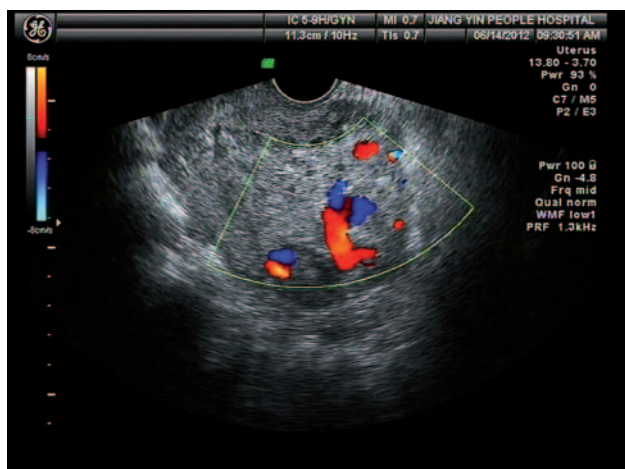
Ultrasound images of a large hematoma, measuring $7.5 \times 6.5 \times 6.1$ cm, in the anterior wall of the middle-lower uterine cavity. Color Doppler flow images (CDFI) show large serpiginous vessels within the mass.
